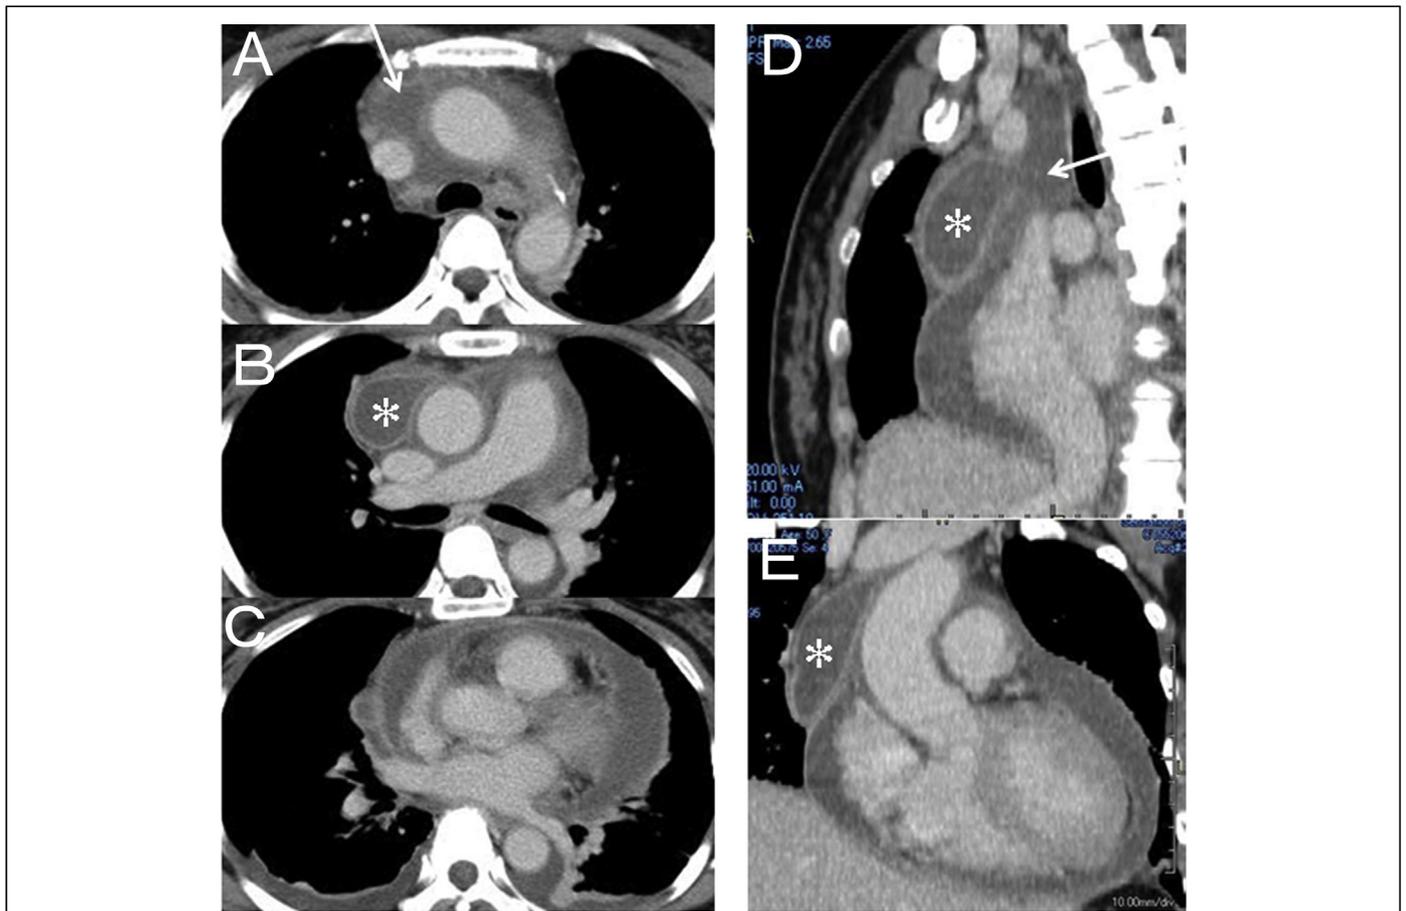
Multi-planar reconstruction images of chest contrast computed tomography in the present case obtained on admission the axial plane (A, B, and C), left anterior oblique plane (D), and coronal plane (E). They showed the mediastinal mass (asterisk) and pericardial effusion, which had the communication (arrow). So, we made a diagnosis of pericardial diverticulum.
